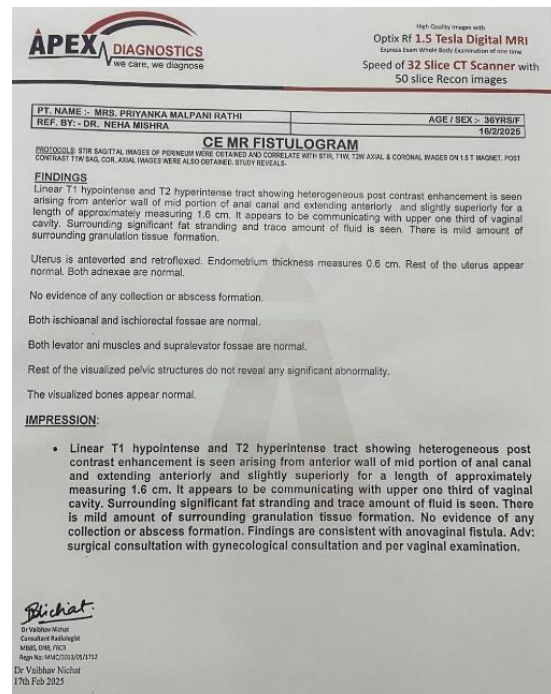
MRI report of Anorectal fistula
